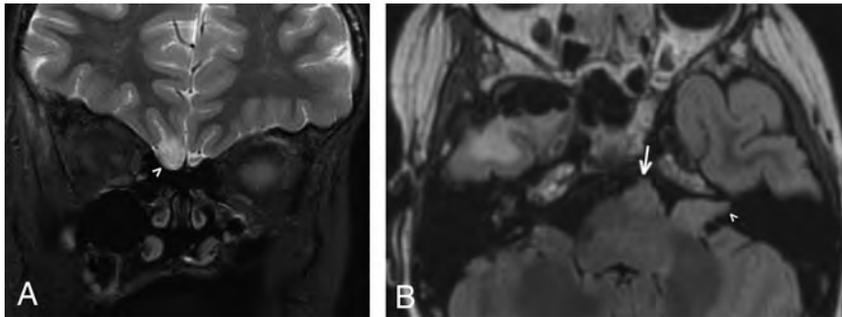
A 10-year-old boy with right anterior temporal grade III anaplastic astrocytoma detected 8 years prior (case 5). Coronal FLAIR image (A) demonstrates a nonenhancing masslike signal abnormality within the right olfactory tract (*arrowhead*), while an axial FLAIR image (B) obtained at the same time demonstrates a nonenhancing masslike signal abnormality within the left internal auditory canal (*arrowhead*) as well as in the prepontine cistern, along the presumed location of the left abducens nerve/CN VI (*arrow*). Combined, findings are compatible with leptomeningeal disease spread involving multiple cranial nerves.
